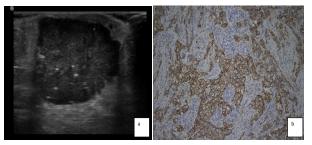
A) Ultrasound Imaging of HER2 (+): Presence of Calcification; Absence of Echogenic halo. B) Result of IHC: HER2-Positive
